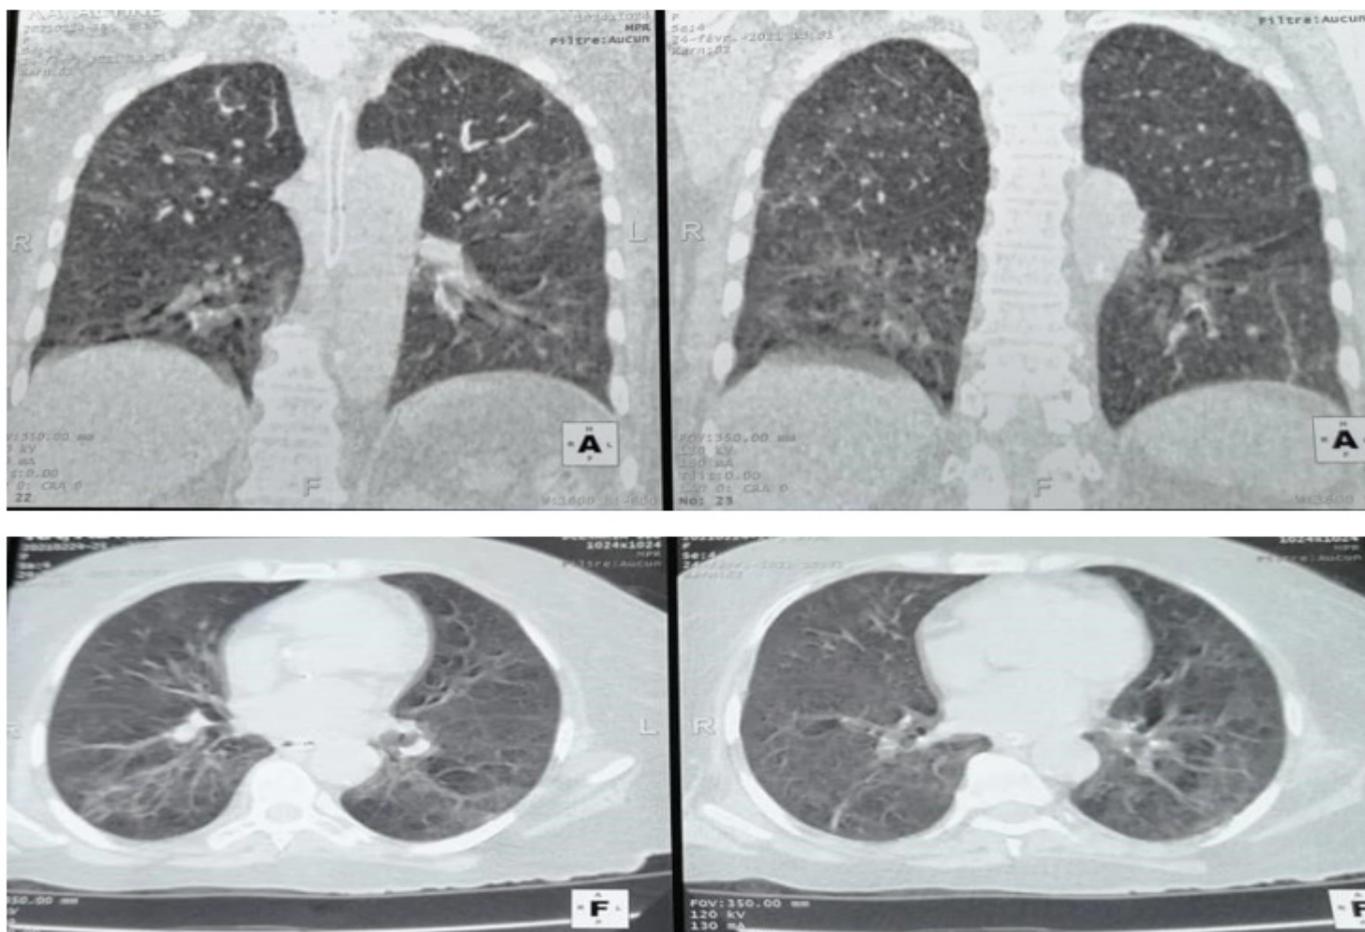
Chest CT: bilateral ground glass appearance.
